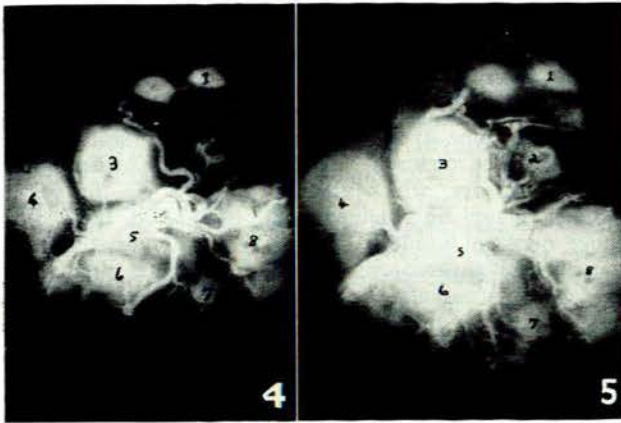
X-ray after about 120 ml. of radio-opaque dye and 80 ml. of liquid latex had reached the IVS via the right uterine artery and spiral arterioles. In addition the umbilical arteries and their ramifications were also partially injected.
